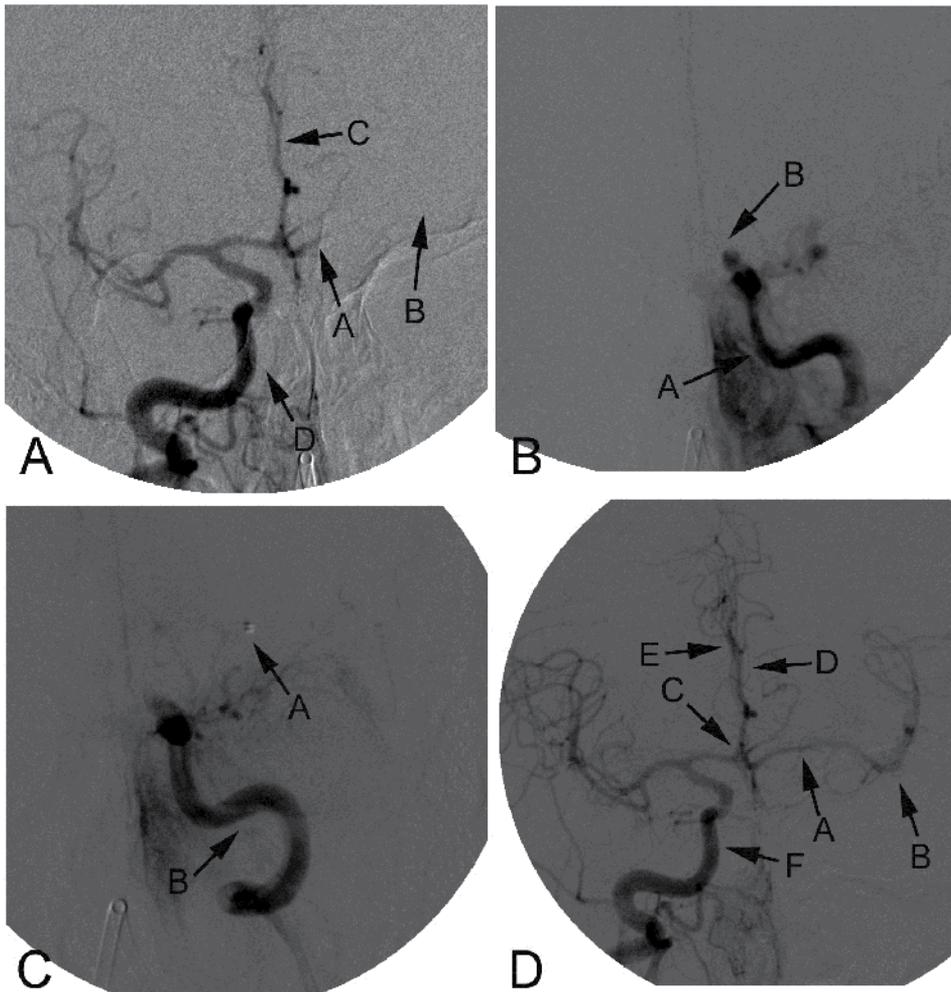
A 65-year-old man presented with an acute stroke with occlusion of his left ICA. He was beyond the window for intravenous thrombolysis. His ancillary studies suggested potentially viable brain in the MCA territory. However, computed tomographic angiography suggested occlusion of the left MCA territory in addition to more proximal carotid occlusion. An emergent angiogram was planned. (A) A right carotid (D) angiogram performed to assess cross-flow reveals a left ICA terminus occlusion (A) with flow to the bilateral distal ACA circulation across the ACoA (C) but no flow to the left MCA (B). (B) Selective left ICA angiogram reveals complete cavernous occlusion (B) of the left ICA (A). (C) The occlusion (B) was carefully crossed, and a thrombectomy suction catheter (A) was advanced into the occluded left MCA. (D) Following suction aspiration, the clot was retrieved from the MCA (B), resulting in revascularization of the ICA terminus (A) and reestablishment of flow across the ACoA (C) from the right ICA (F). Both ACAs remained patent (E, D). Despite these efforts, the proximal occlusion remained recalcitrant to revascularization efforts and was therefore left occluded. The patient recovered from all deficits.
